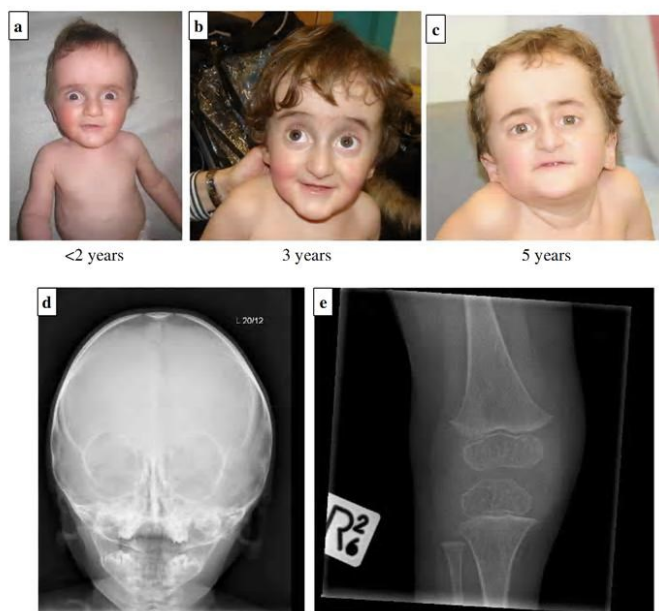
Panels a–c: Facial appearance of Patient 2 aged <2, 3 and 5 years demonstrating similar facial dysmorphism to Patient 1 with progeric appearance, grey sclerae, broad forehead, bilateral low-set ears, proptosis; panels d–e: Skull and right lower limb X-rays demonstrating thin skull vault, slender bones and osteopenia.
